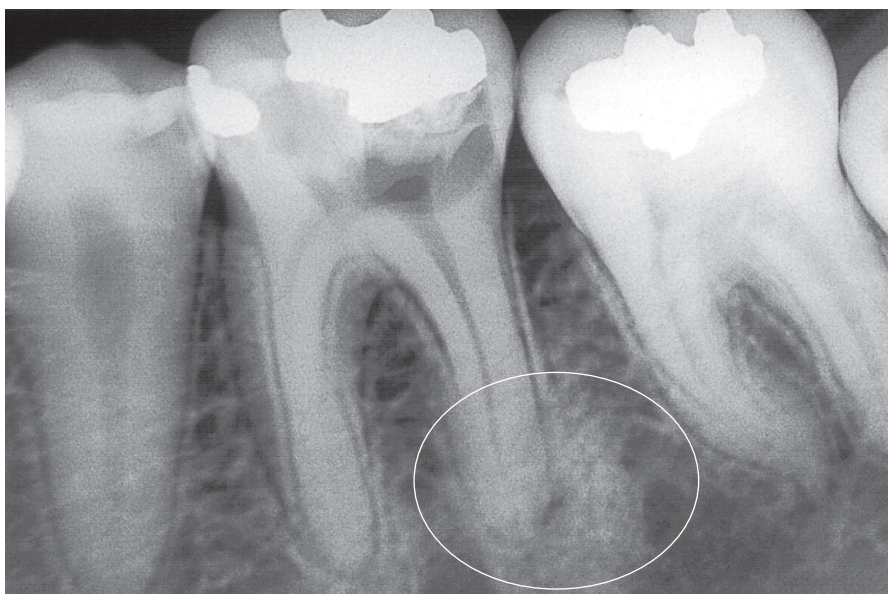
In periapical bone tissue, inflammation corresponds to chronic focal sclerosing osteitis related to necrotic pulp and chronic inflammatory periapical lesions. Radiopaque areas are predominant, corresponding to thickening of trabeculae and reduced marrow spaces. Smaller and irregular rarefying areas immediately around the opening of the root canal in which the low intensity and long duration aggressors come out. From a clinical and dental point of view, these signs can be diagnosed as chronic inflammatory periapical lesions compatible with periapical granuloma. There was no fistula.
